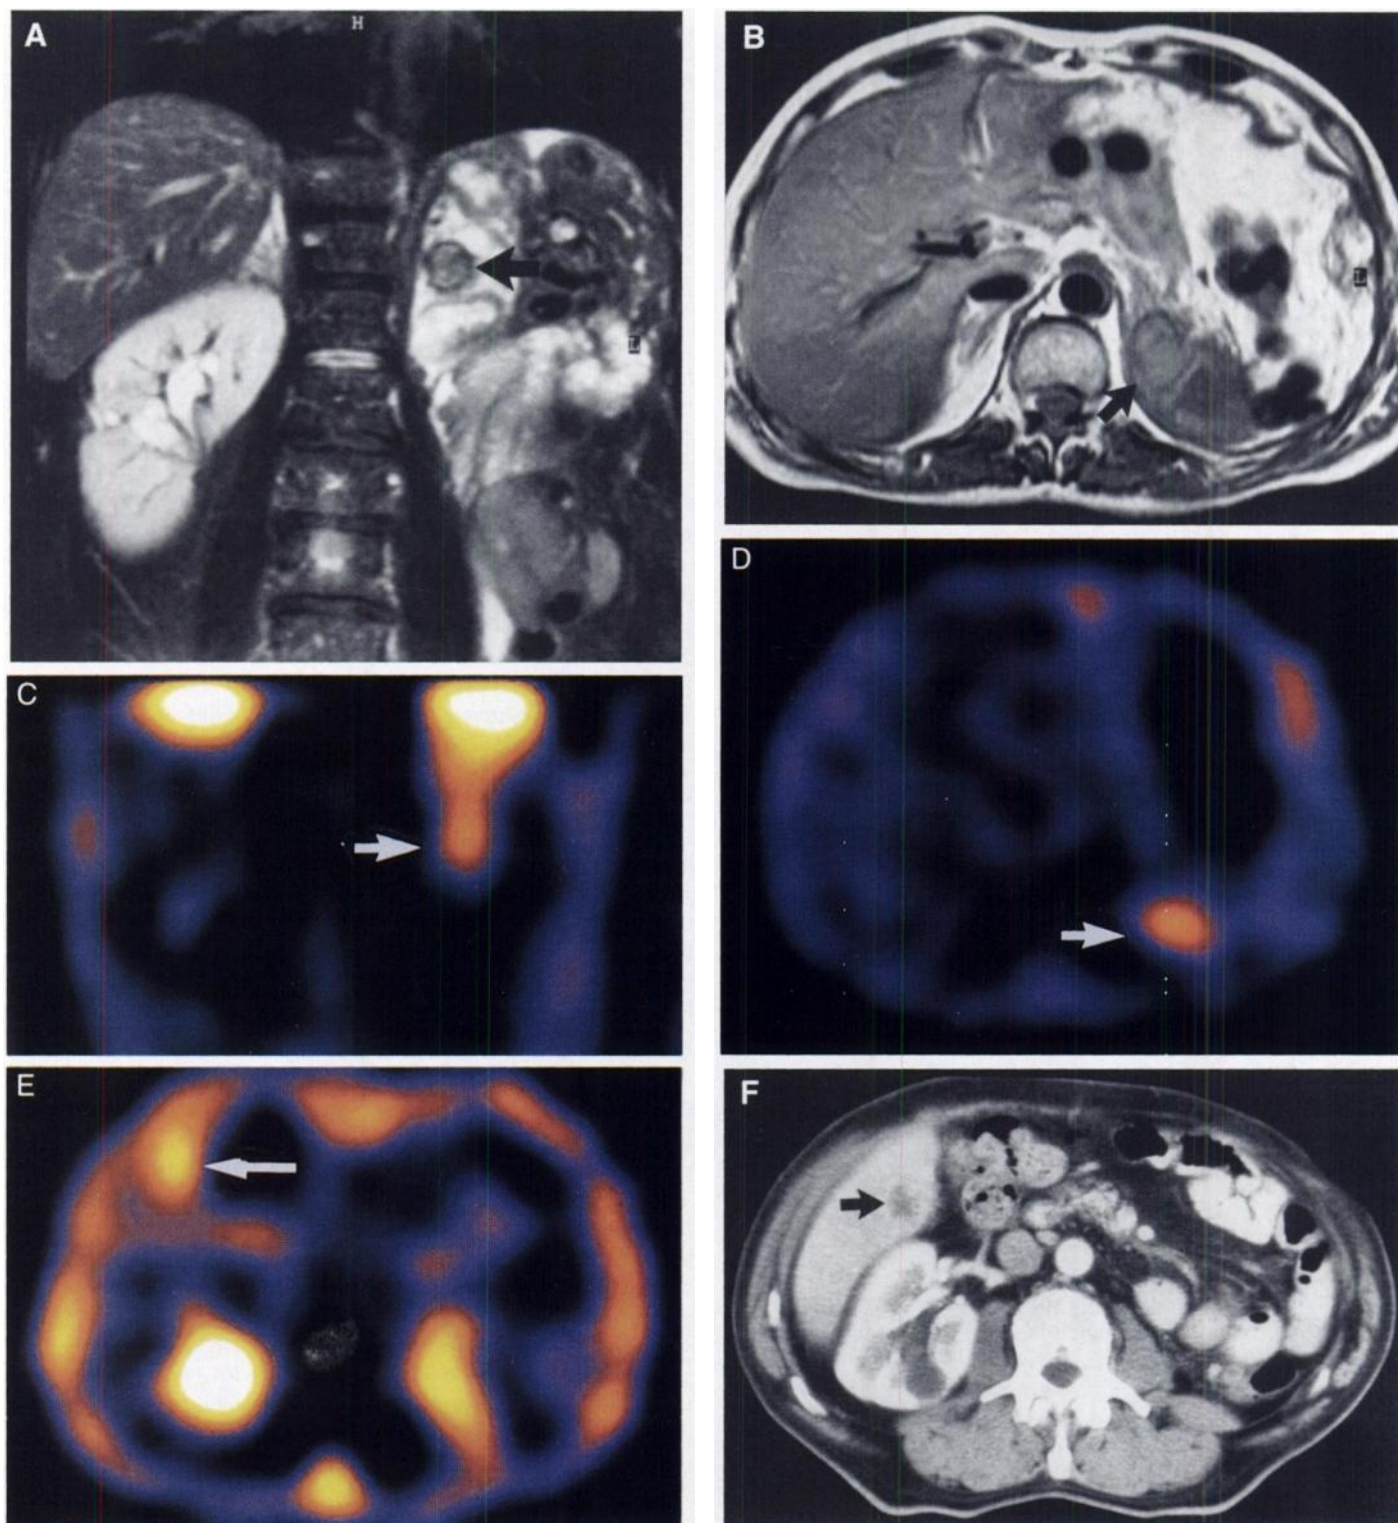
Primary pancreatic cancer as imaged by ^{123}I -VIP. Primary CT-negative tumor as seen by MRI on a coronary (A) and transverse (B) slice in a male patient with pancreatic cancer (arrow) who had undergone nephrectomy on the left side due to cystic kidney disease 12 yr before. SPECT reconstruction 4 hr postinjection of ^{123}I -VIP showing the pancreatic cancer (arrow) seen on a coronary (C) and transverse (D) slice. Single liver metastases in the same patient as seen on a coronary slice (E) after injection of ^{123}I -VIP and by CT (F).
